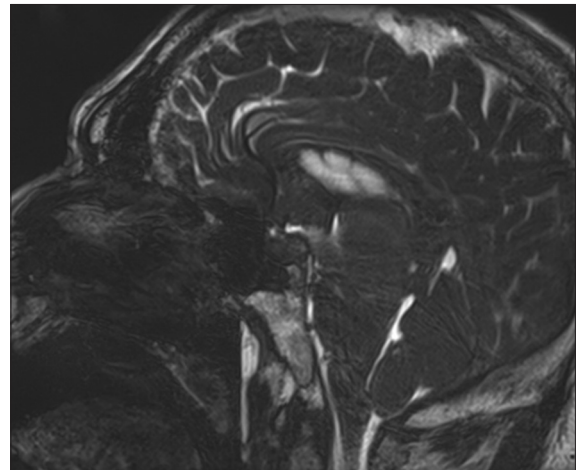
Sagittal T2 MR image showing diffuse edema of the brain stem and an obliterated 4th ventricle in the posterior fossa
